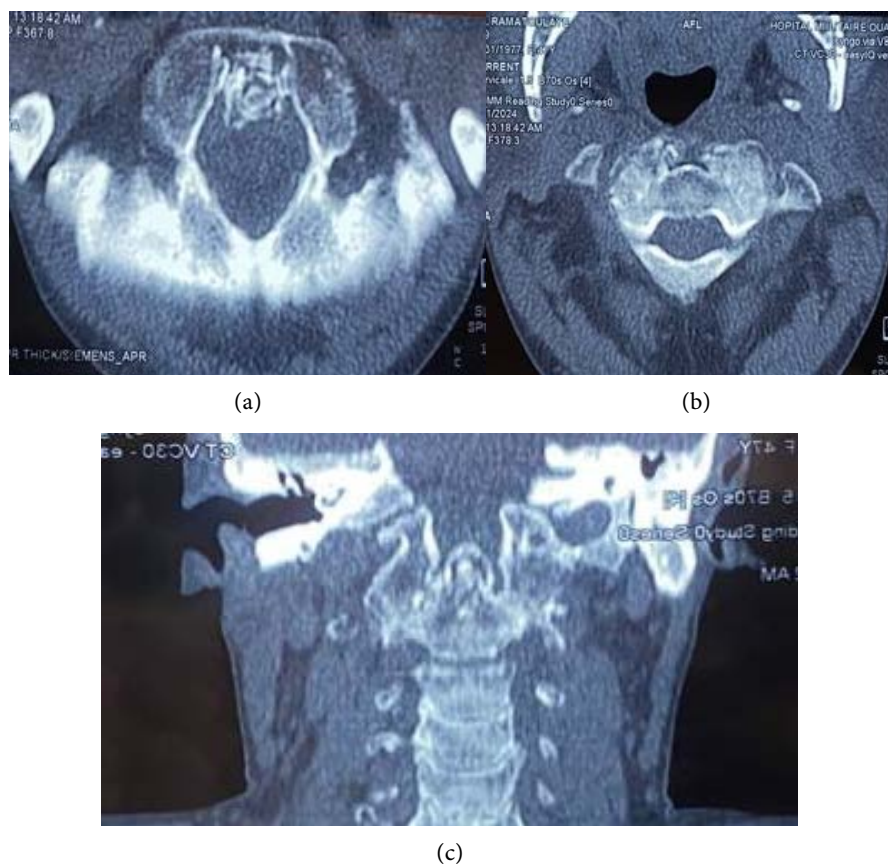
Cervical CT in our patient showing fusion of the associated atlanto-axoid joint with erosions and geodes at the edges of the anterior arch of C1. No atlantoaxial dislocation detected ((a) and (b): axial section; (c): frontal section).
